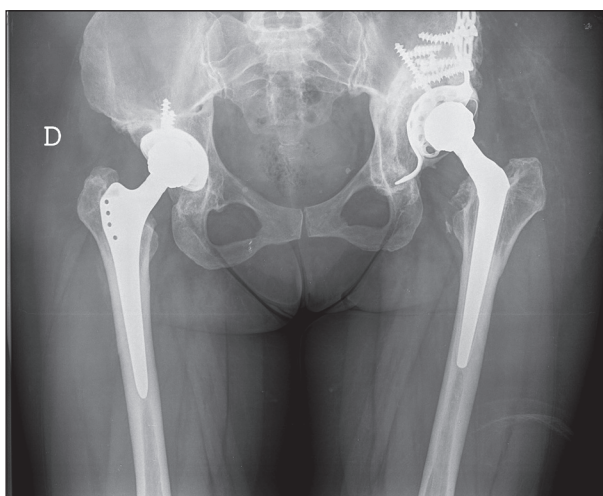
Case 3. Preoperative DE x-ray. Loosening of Burch Shneider revision cage three years before third hip revision
